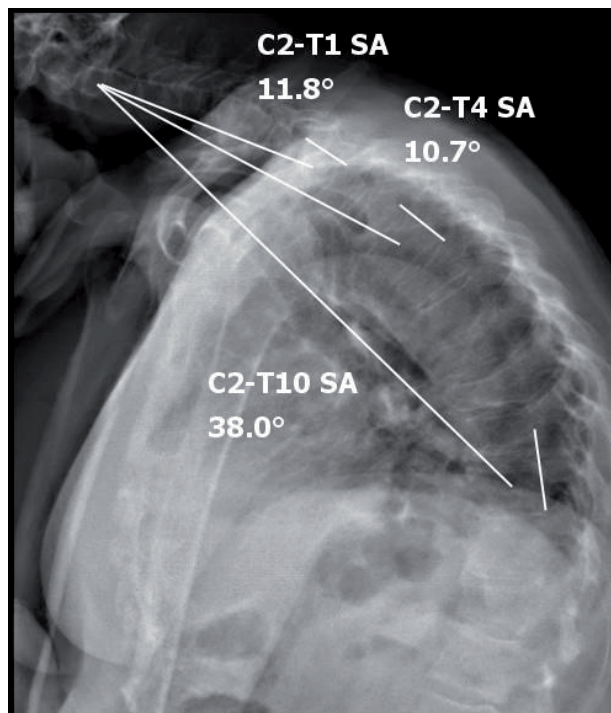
Sagittal radiograph of a patient showing the measurement of C2-T1 SA, C2-T4 SA and C2-T10SA.
